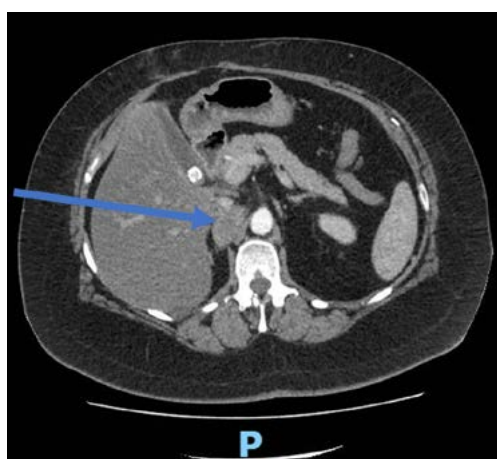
Pre-treatment CT scan showing right upper abdominal node measuring 25mm on 10th January 2020
